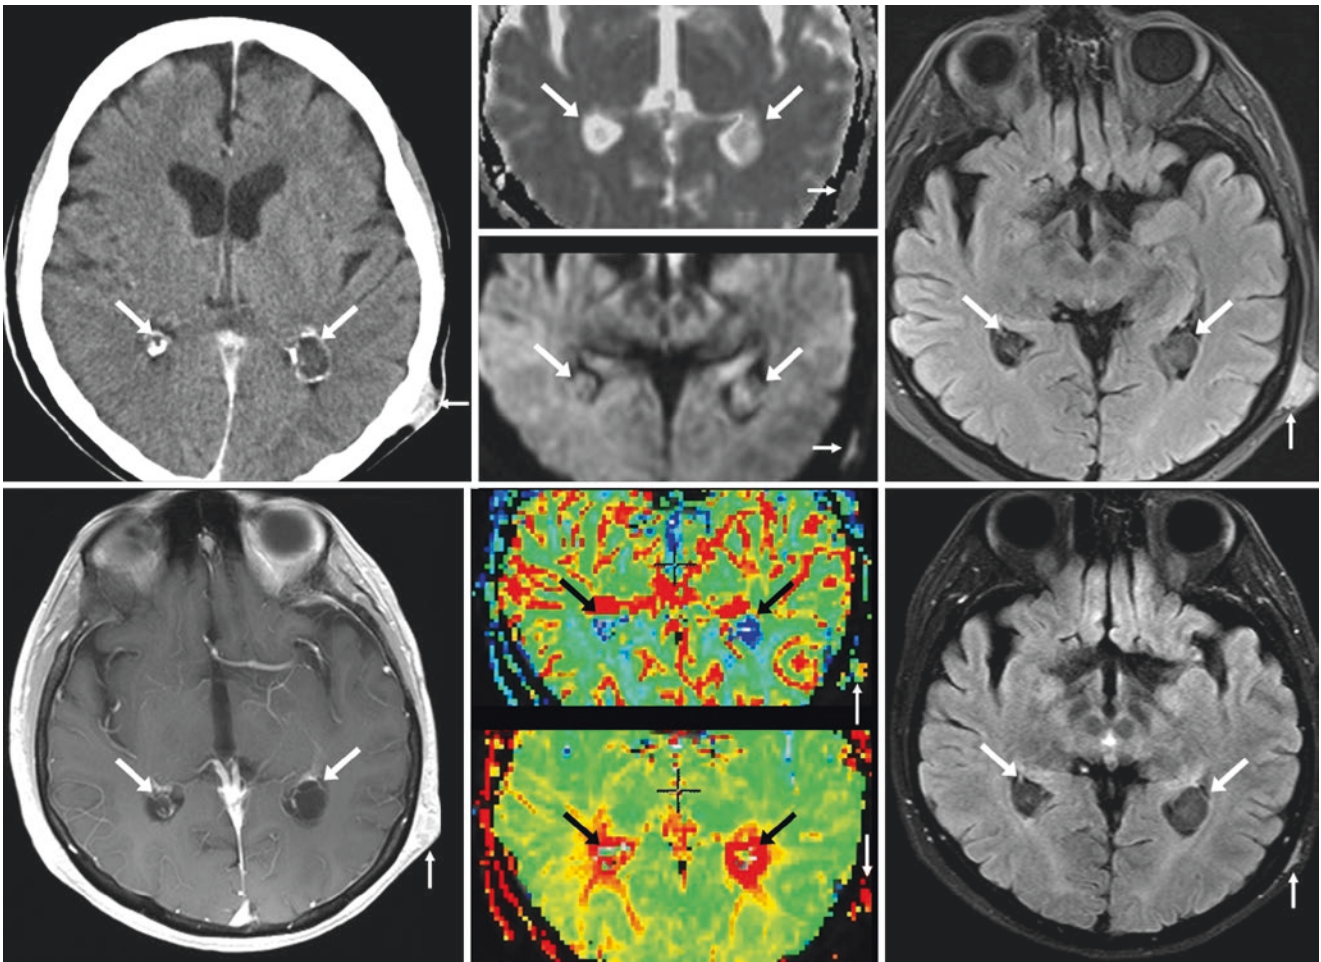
A 70 year old had a NECT (*top left*) that showed bilateral CPXGs (*arrows*). A 3 T MRI performed to evaluate a left scalp malignancy (*thin arrows*) depicted the CPXGs within the atria of the lateral ventricles on axial DWI and their ADC maps (*top, middle images*), with intermediate signal on FLAIR (*top right*) and peripheral enhancement
